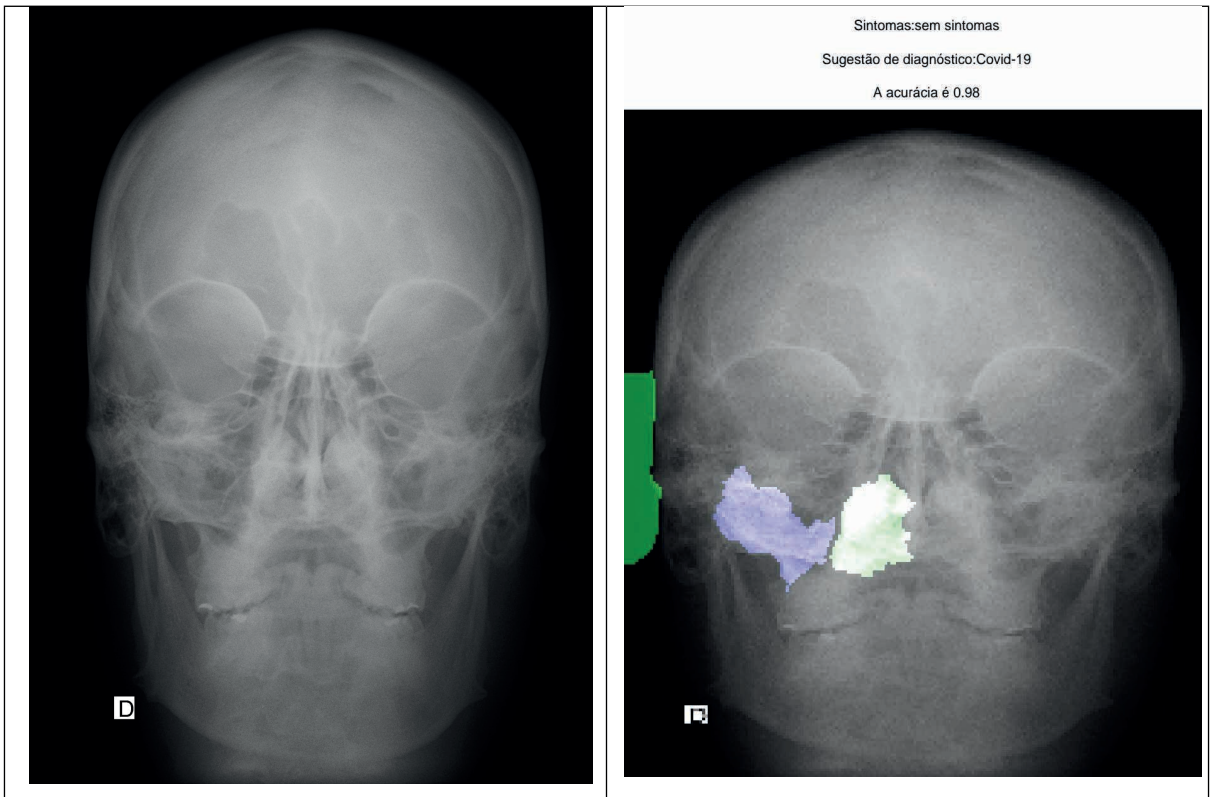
(A) Chest X-Ray image of skull PA: front; (B) Identification of Covid-19 changes in maxillary sinuses.
